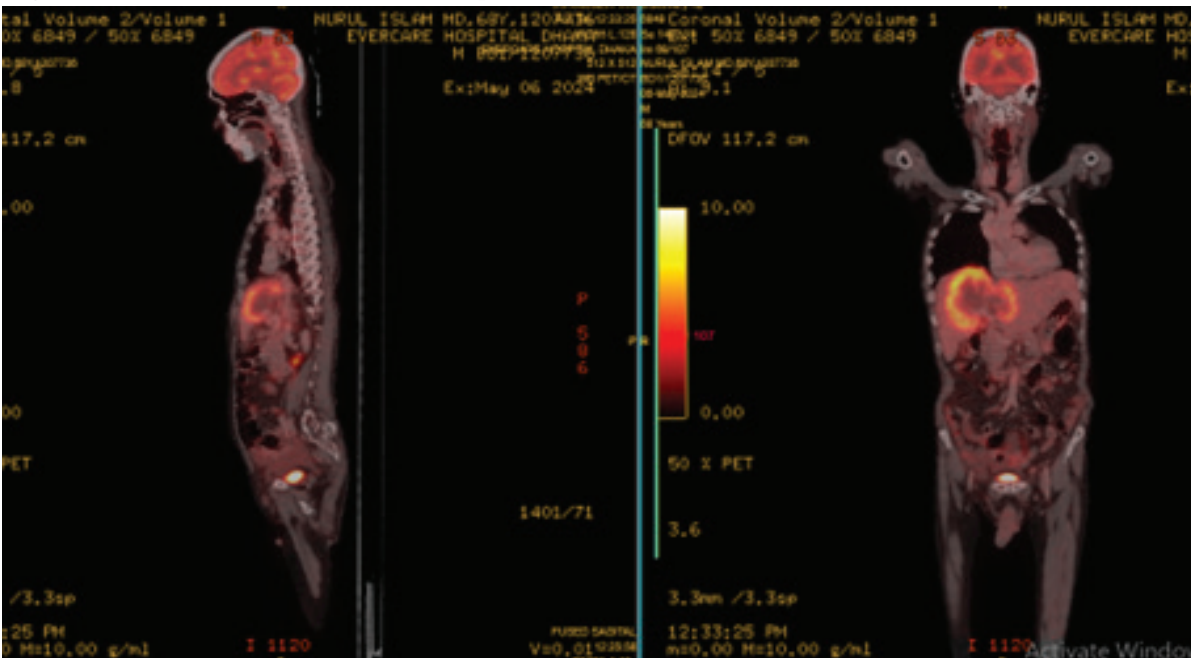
In sagittal and coronal scans show no abnormal FDG avidity in larynx. There is large high FDG avid mass is liver.
